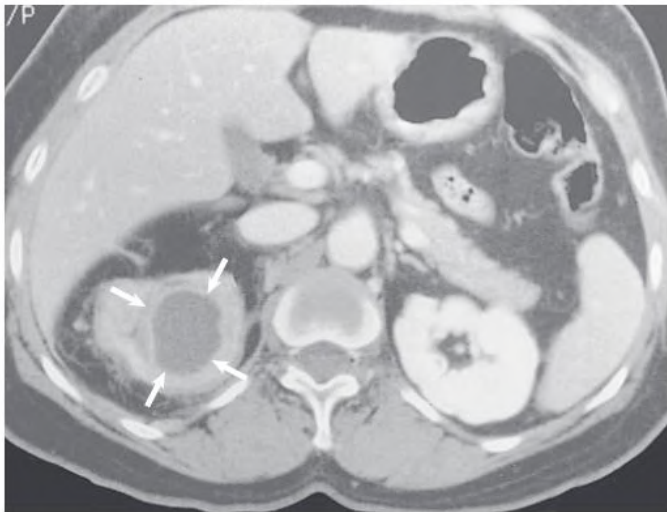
Xanthogranulomatous Pyelonephritis. Contrast-enhanced computed tomography scan with an inflammatory mass outlined by arrows. Pathologic diagnosis confirmed xanthogranulomatous pyelonephritis. (Courtesy W. Bush, University of Washington, Seattle.)
